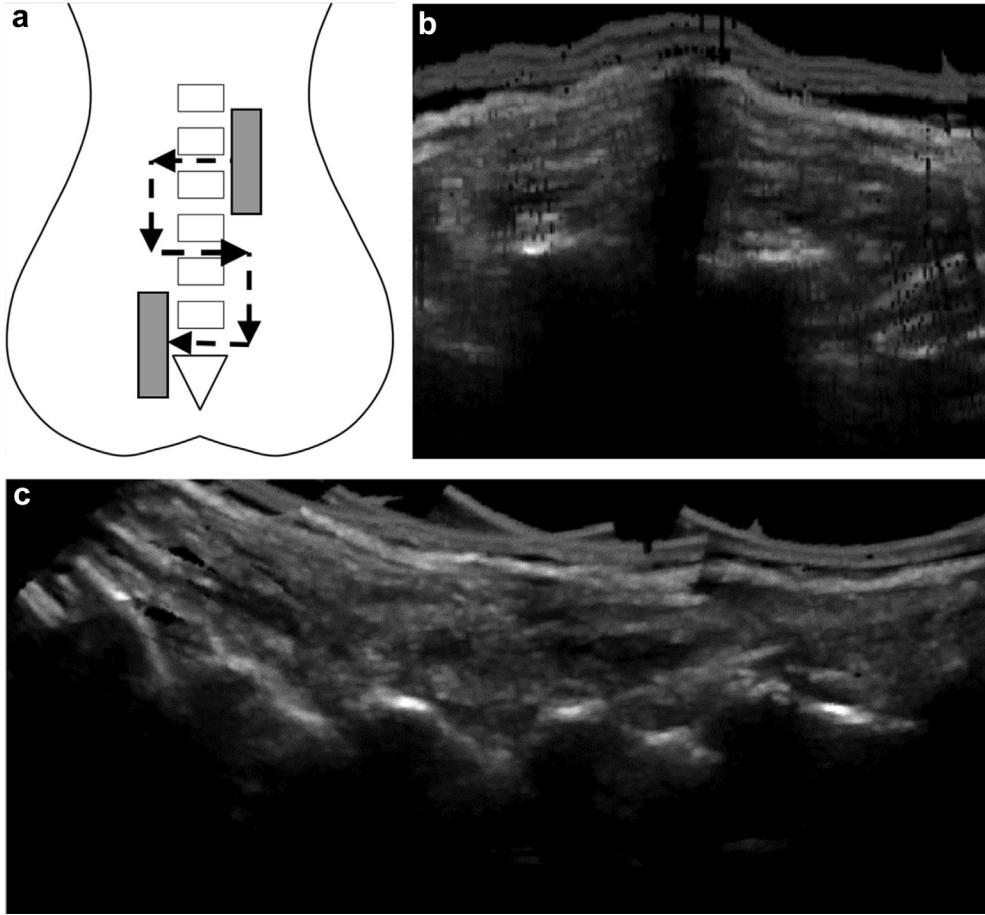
Ultrasound volume acquisition. (a) The electromagnetically tracked transducer was moved laterally and from superior to inferior in a zigzag pattern, acquiring ultrasound slices in sagittal orientation. The zigzag scan was used as it was found to be easier to perform and provided high-quality images of the spine, covering the full extent of the vertebrae, the full extent of the lumbar spine and a small consistent overlap between sweeps. Slices of the reconstructed volume are shown for a transverse re-slice orientation in (b) and a sagittal re-slice orientation in (c).
